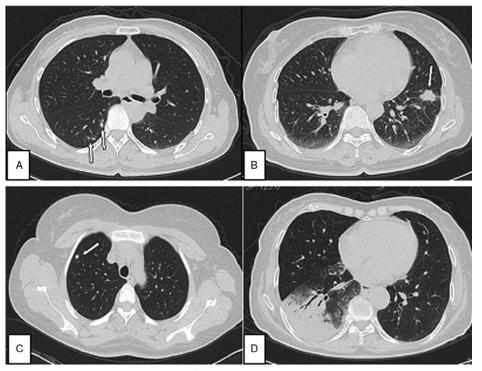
A: Chest CT showing a small nodular shadow in the right S^1 (green arrow, patient 5). B: Chest CT showing a nodule with lobulation sign in the left $S^{7,8}$ (green arrows, patient 2). C: Chest CT showing a large flake-like infiltrated shadow in the right lower lobe (green arrow, patient 8). D: Chest CT showing multiple small nodules in the right S^6 (patient 7).
